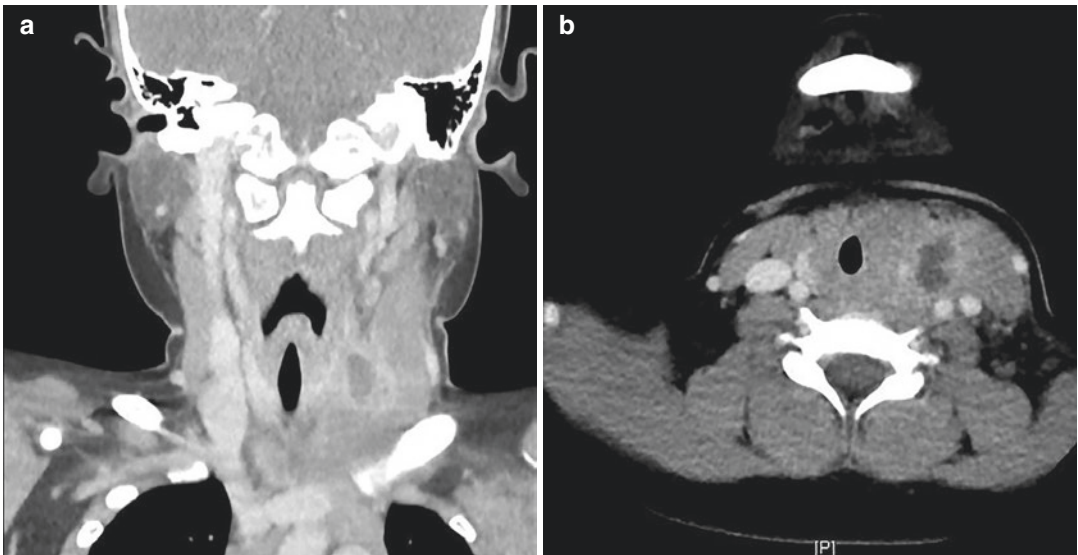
Head and neck CT scan for the first episode revealed a 2.9 × 2.6 × 2.3 cm irregular rim-enhancing fluid collection in the left neck abutting the left thyroid gland in coronal plane (a) and axial plane (b)
